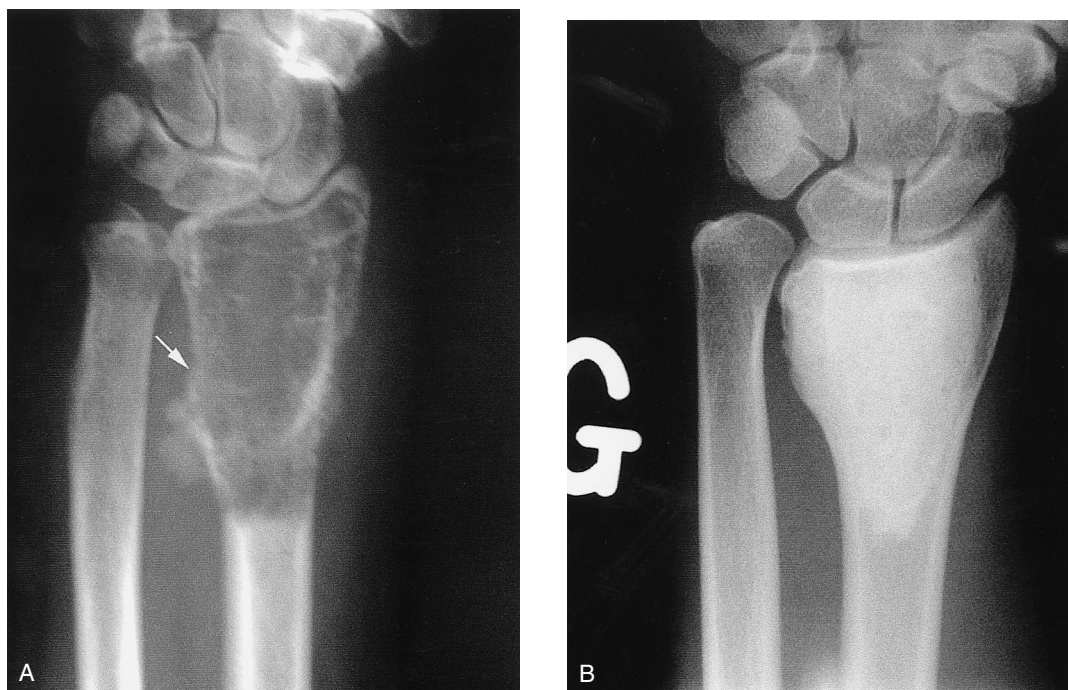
(A) A radiograph of a Stage 3 giant cell tumor in a 67-year-old woman with a pathologic fracture (arrow) is shown. (B) A radiograph shows the result 5 years after curettage, phenol, and cement. No significant joint narrowing can be seen.
